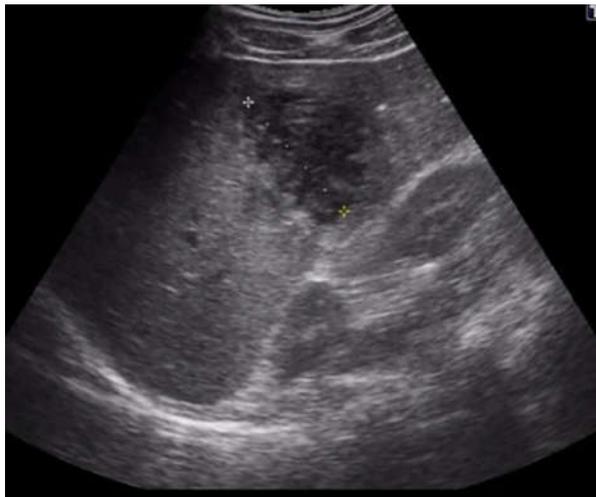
Ultrasound of liver showing a well-defined, heterogeneous hypoechoic lesion (marked by white arrows) measuring approximately 5.6 × 6.8 × 8.8 cm in the right lobe of the liver
